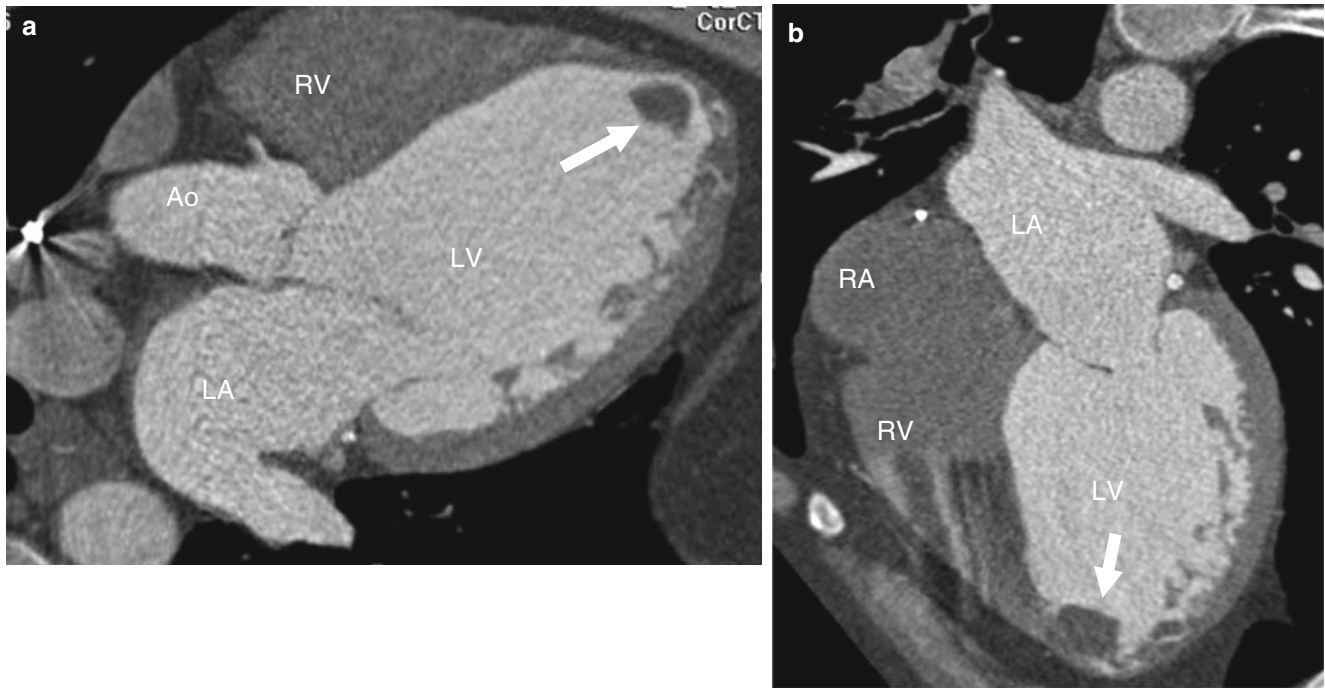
Left ventricular thrombus in a 50-year-old woman who suffered a recent myocardial infarction. Panels (a) and (b) are two long-axis contrast-enhanced CT scans showing a homogeneous soft tissue mass (arrow) in the apex of a dilated left ventricle (LV). The thrombus
